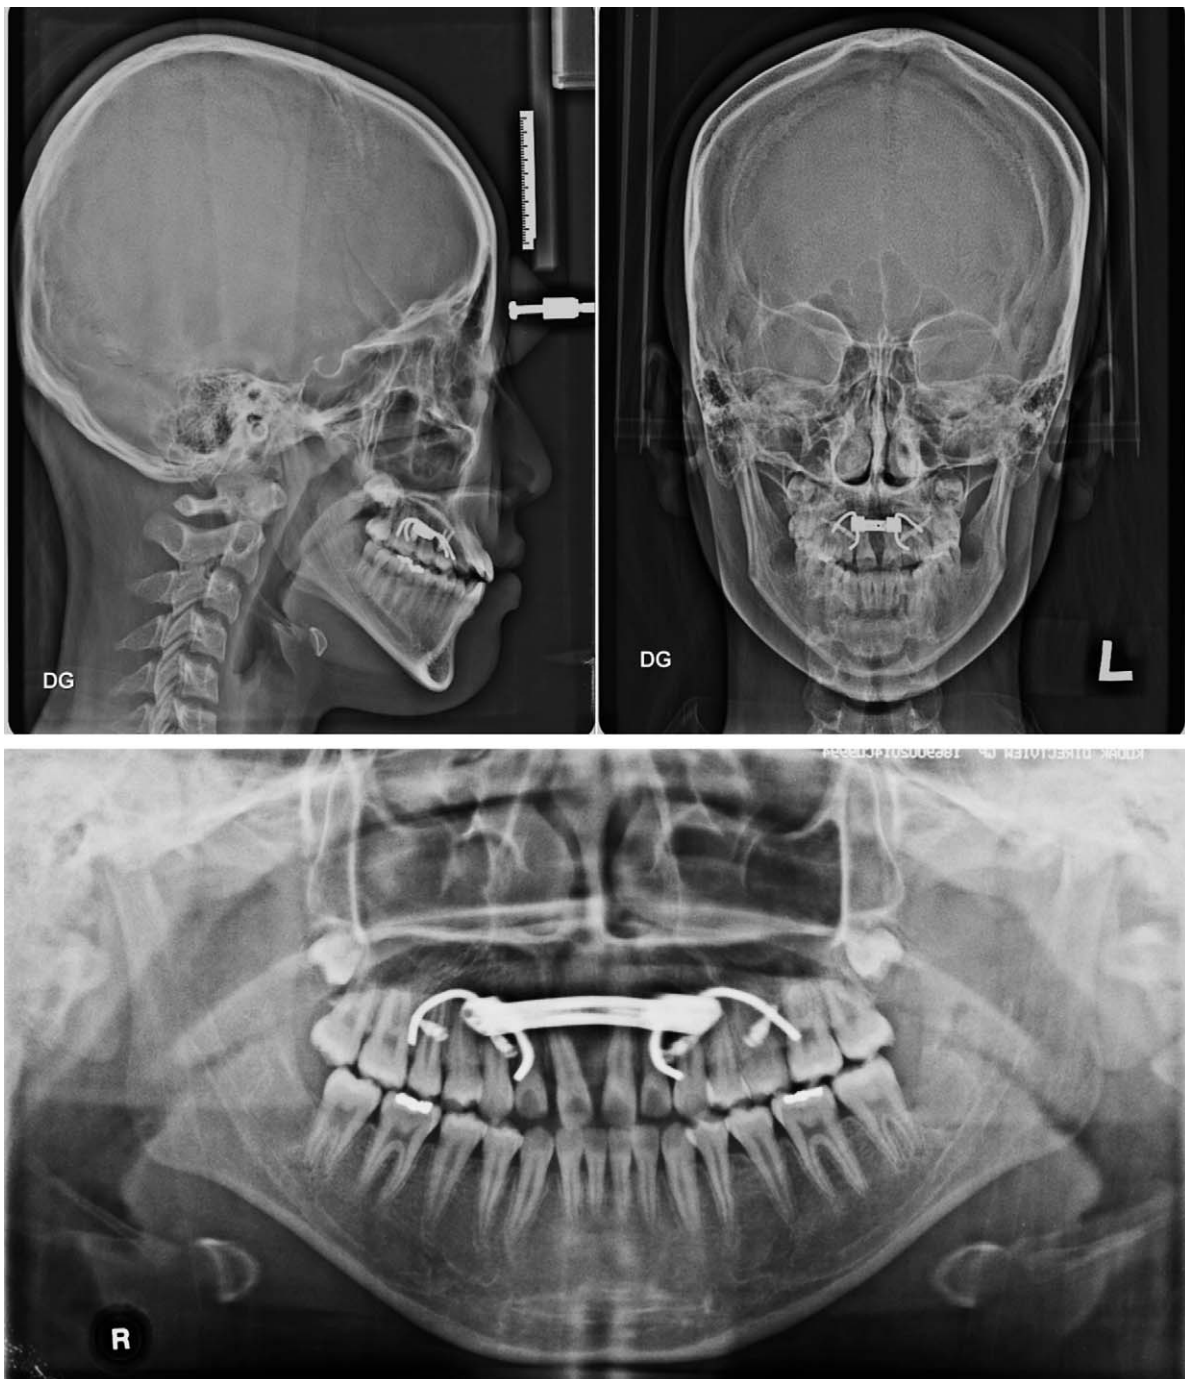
Midtreatment radiographs after maxillary expansion: lateral and posteroanterior cephalograms, panoramic radiograph.
